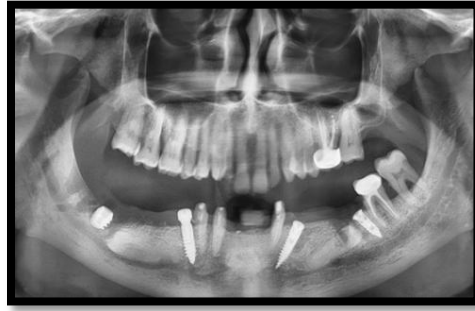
Radiographic view of the implants placed
